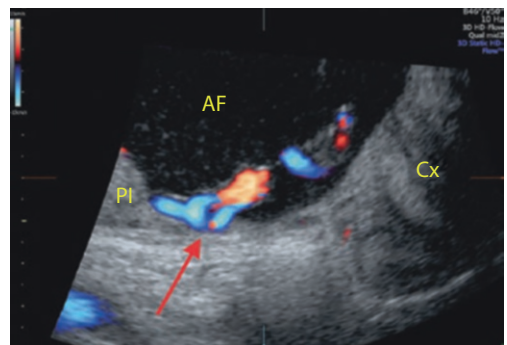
Vaginal ultrasonography and color Doppler of the lower uterine segment showing the cervix (Cx), amniotic fluid (AF), lower pole of a posterior placenta (Pl), and marginal umbilical cord insertion (red arrow) at 21 weeks gestation
